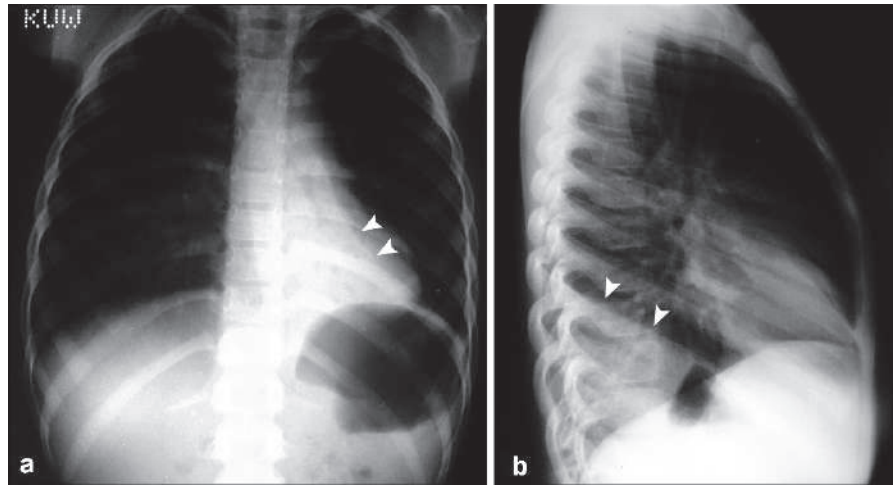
Posteroanterior (a) and lateral (b) plain chest radiographs show left upper lobe (LUL) atelectasis. Notice the high density left lung field in (a), which is explained by atelectasis of the LUL anteriorly in (b) (arrowheads)
